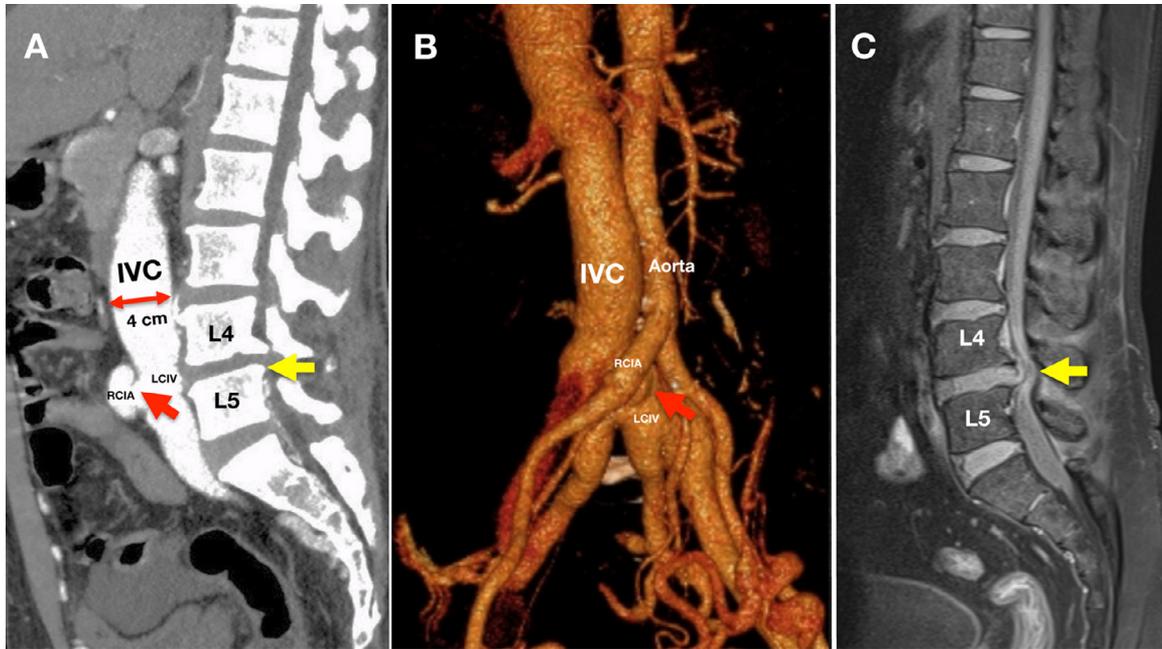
Computed tomographic angiography of the whole aorta and magnetic resonance imaging of the lumbar spine. (A) Computed tomographic angiography of the whole aorta in sagittal view shows the arteriovenous fistula (red arrow) from the right common iliac artery to left common iliac vein at L4-L5 level (yellow arrow). There was a significant shunting to the venous system causing the marked dilatation of the inferior vena cava. (B) 3D reconstruction in the coronal view shows the anatomic relationship of the fistula (red arrow). (C) The preoperative lumbar magnetic resonance imaging performed 5 years ago demonstrates the location of the herniated disc at the L4-L5 level (yellow arrow), which corresponds to the location of the fistula in panel (A).
